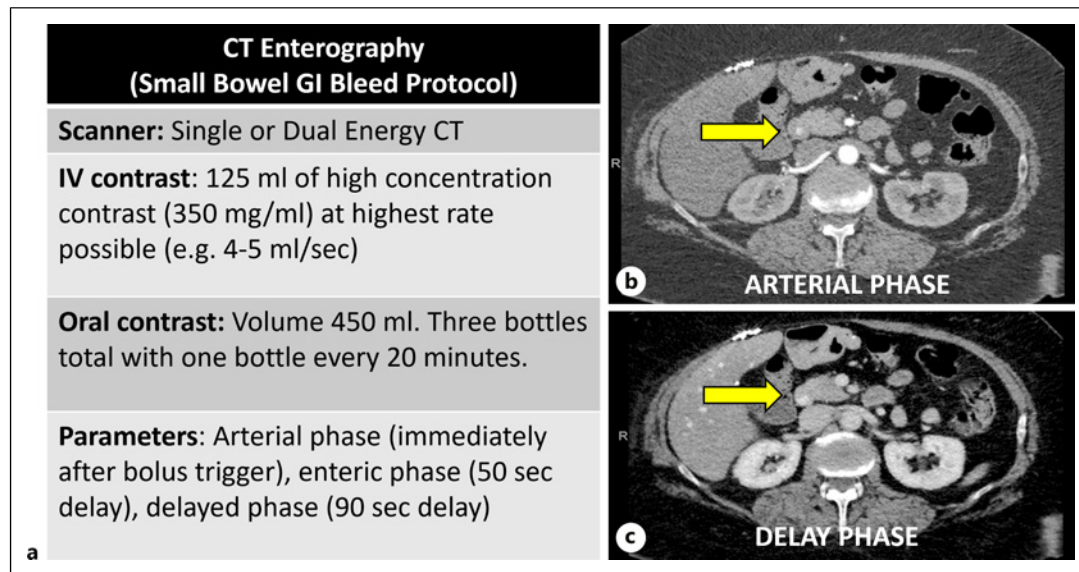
a CT enterography with specialized small bowel GI bleed protocol designed by TJUH. b, c GI bleed in the duodenum visualized as a blush in the duodenal lumen on both the arterial and delay phase of CT enterography with small bowel GI bleed protocol. CT, computerized tomography; TJUH, Thomas Jefferson University Hospital.
